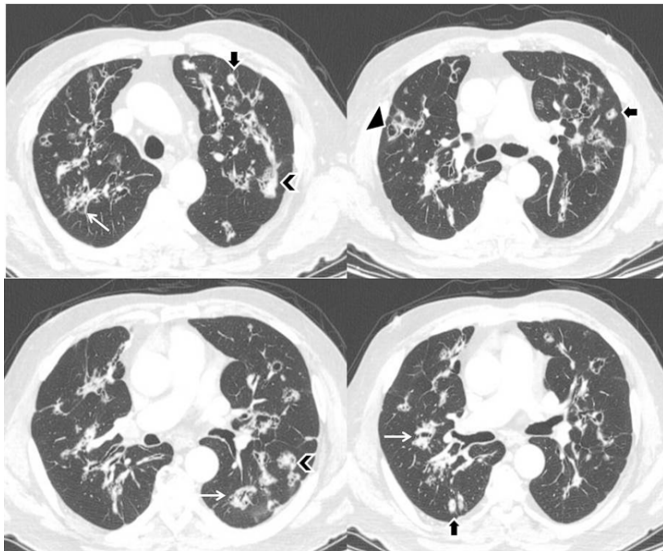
Thin-section computed tomography scans through different sections demonstrate radiolucencies (thin arrows) mimicking pseudocavitations, thin wall cavities (arrowheads), nodules (square brackets) surrounded by a halo of ground-glass attenuation (halo sign) and nodules with central lucency – the ‘Cheerio sign’ (thick arrows)
